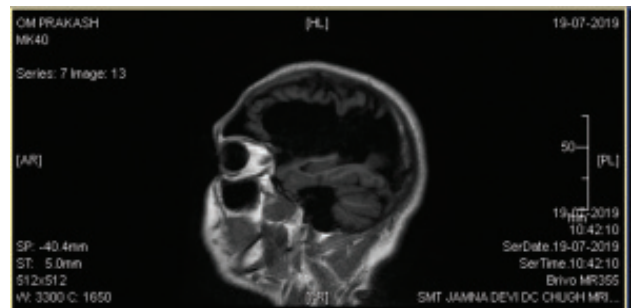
MRI brain showing hyperpneumatization of frontal and maxillary sinuses.
